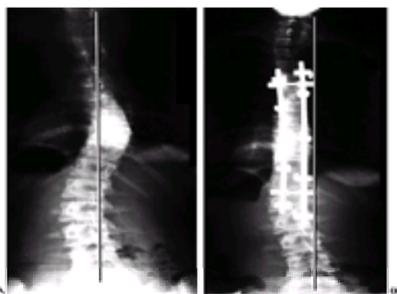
A: The preoperative PA radiograph demonstrates the stable vertebra to be at T12. B: The patient was instrumented posteriorly to L1 with a down-going hook at the distal end on the left side, resulting in decompensation to the left. This could have been prevented by either stopping the instrumentation at T12 or reversing the direction of the left-sided L1 hook to up-going.
